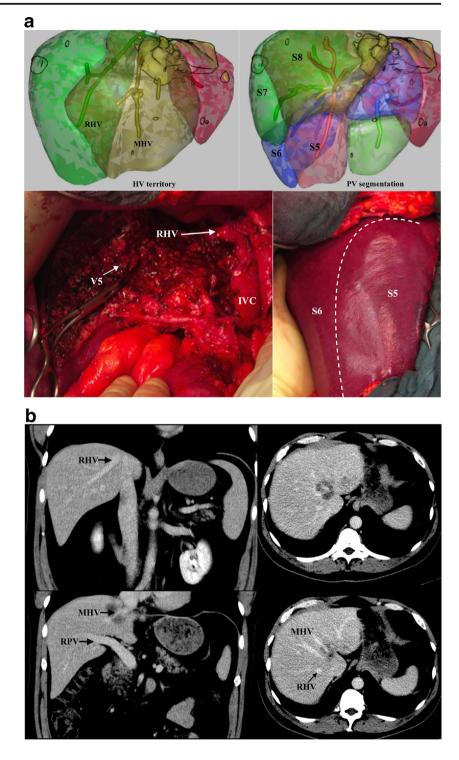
Resection of the main trunk of the middle hepatic vein (MHV) but not the venous tributary of segment 5 (V5) was performed according to the preoperative CT study (b). A vascular clamp was kept in segment 5 for an optional reconstruction which was found not necessary at the end of operation. The 3D reconstruction study of the CT scan and intraoperative ultrasound showed that V5 drains into MHV (a)
